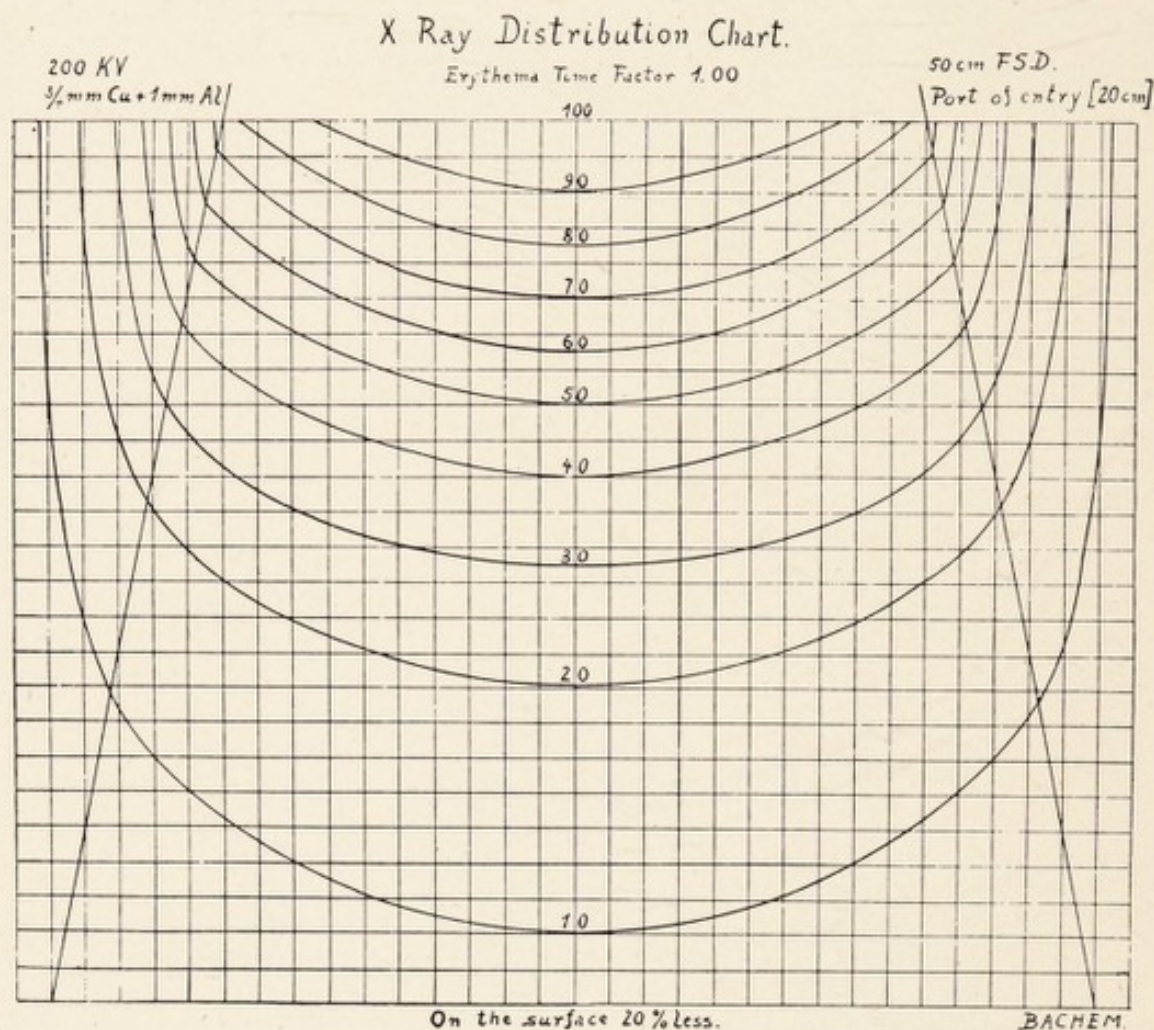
X-RAY EQUAL INTENSITY CURVES IF PORT OF ENTRY IS 20 CM.<sup>2</sup>
